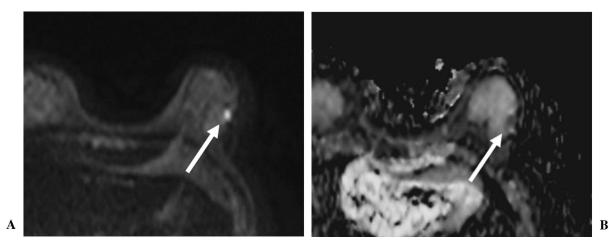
A 49-year-old woman with left breast cancer diagnosed as axillary lymph node (N)-positive, nuclear grade (NG) 1, estrogen receptor (ER)-positive, progesterone receptor (PgR)-positive, and human epidermal growth factor receptor 2 (HER2) score 0. (A) A nodule with high signal intensity was detected in the left breast on diffusion-weighted imaging (DWI) (arrow). (B) The apparent diffusion coefficient (ADC) value was 1.24×10^{-3} mm²/s on the ADC map.
